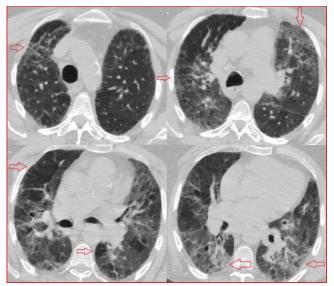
HRCT revealing linear opacities in the central lung areas, increased reticular density, traction bronchiectasis, ground glass densities, mosaic perfusion and air trapping areas in places
